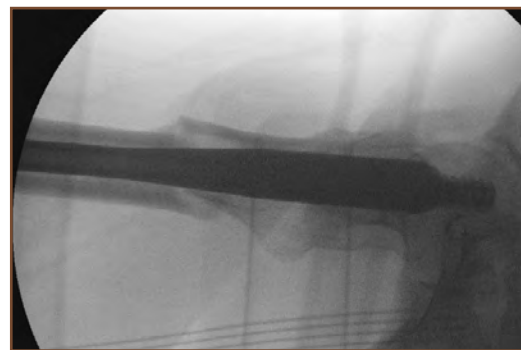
Lateral radiograph of the femur, showing effect of an eccentric (too anterior) piriformis entry site. Notably, the placement results in extension (apex anterior) malreduction of the subtrochanteric femur shaft fracture.
